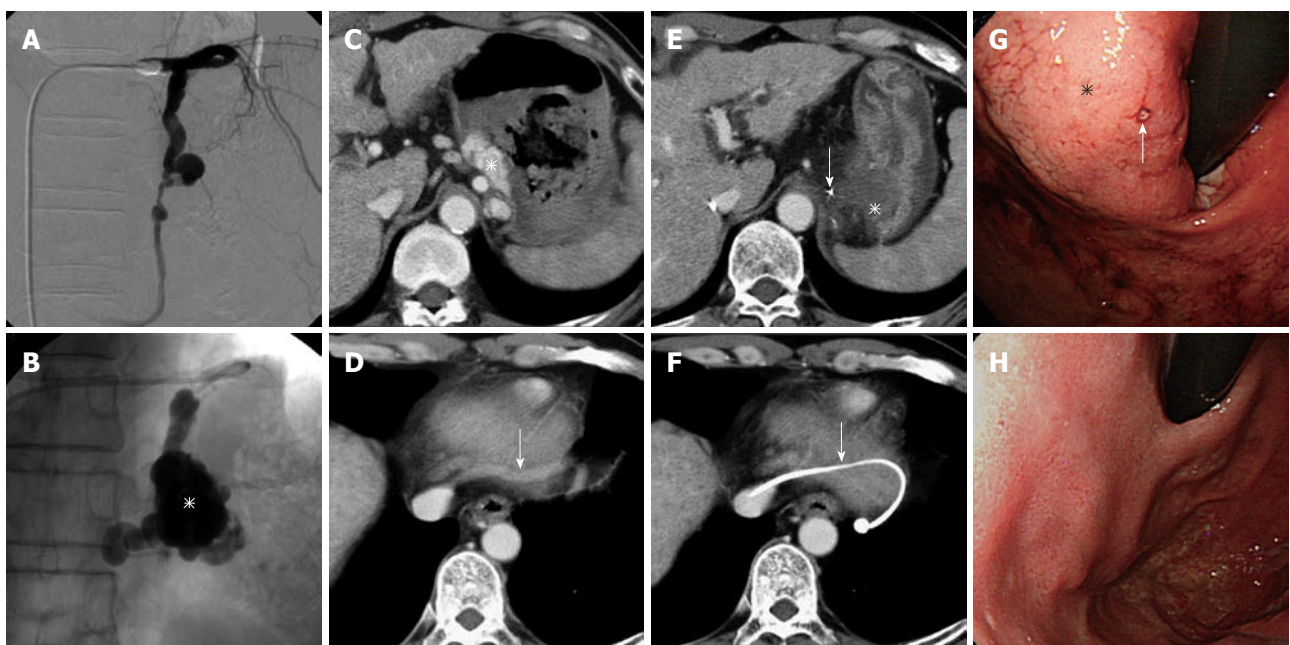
Selective injection of the sclerosant. A: A balloon catheter is inserted into the gastrocaval shunt. Balloon-occluded venography shows no gastric varices; B: The balloon catheter is advanced further into the shunt, and the sclerosant is selectively injected through the microcatheter which is navigated close to the gastric varices. The varices (asterisk) are opacified sufficiently; C: Contrast-enhanced computed tomography (CE-CT) shows the varices (asterisk) and a large amount of hematomas in the stomach; D: The gastrocaval shunt (arrow) flows into the inferior vena cava; E: CE-CT next day shows complete thrombosis of the gastric varices (asterisk) and the tip of the microcatheter (arrow) close to the varices; F: CE-CT shows the balloon catheter in the shunt (arrow); G: Endoscopy before balloon-occluded retrograde transvenous obliteration (BRTO) shows large gastric varices (asterisk) with a bleeding site (arrow); H: Endoscopy 3 mo after BRTO shows complete disappearance of the varices.
